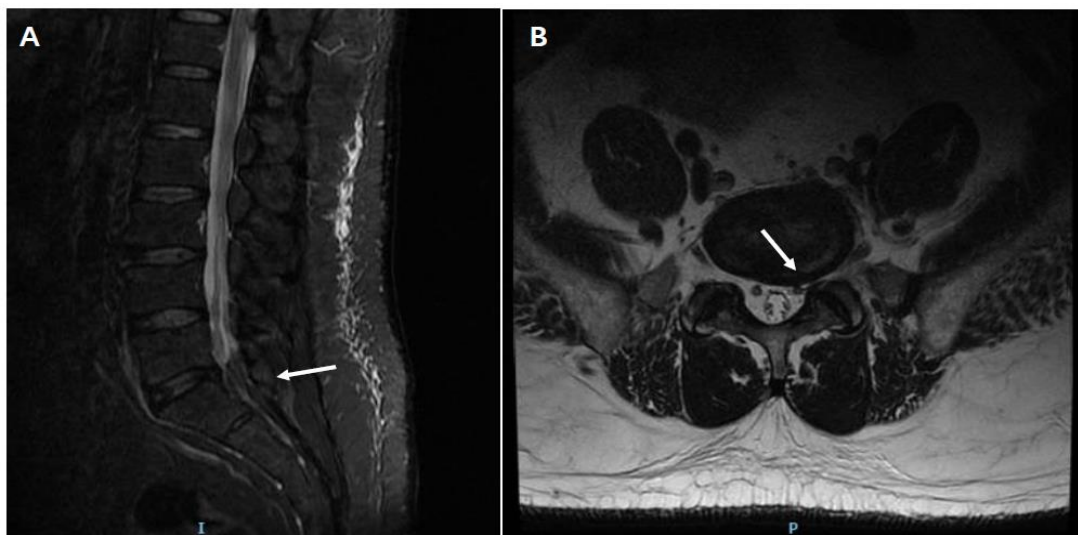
MRI showed L5/S1 foraminal stenosis caused by disc bulging and thickening of ligamentum flavum (arrows).
